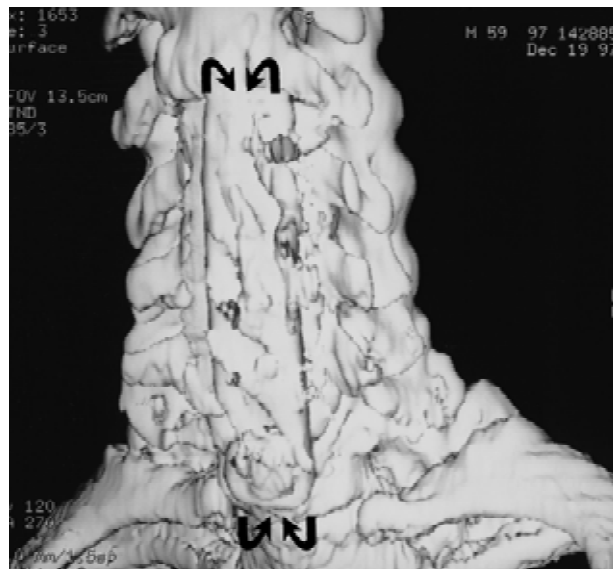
An anterior coronal three-dimensional CT study obtained 1.5 years after operation confirmed incorporation of the anterior Orion plate (case 1). The anterior Orion plate (double arrows), seen on this coronal three-dimensional CT scan obtained 1.5 years after operation, became fully incorporated into the anterior fusion mass.
